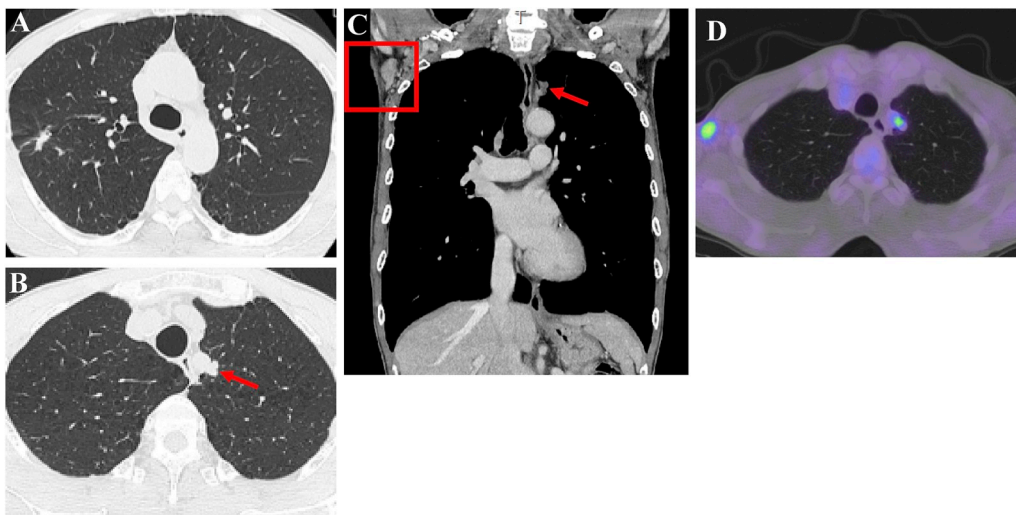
A. Chest computed tomography (CT) revealed a 15-mm irregularly shaped nodule in the upper lobe of the right lung. The nodule shadow was unchanged after 10 months of observation. B. Chest CT revealed a small new 5-mm nodular lesion in the left lung apex, which gradually increased in size over the course of 10 months (red arrow). C. Enlargement of the right axillary lymph nodes, with no enhancement effect (red square). D. Positron emission tomography-CT depicting 18F-fluorodeoxyglucose uptake in the left lung apex and right axillary lymph nodes. (For interpretation of the references to colour in this figure legend, the reader is referred to the Web version of this article.)
